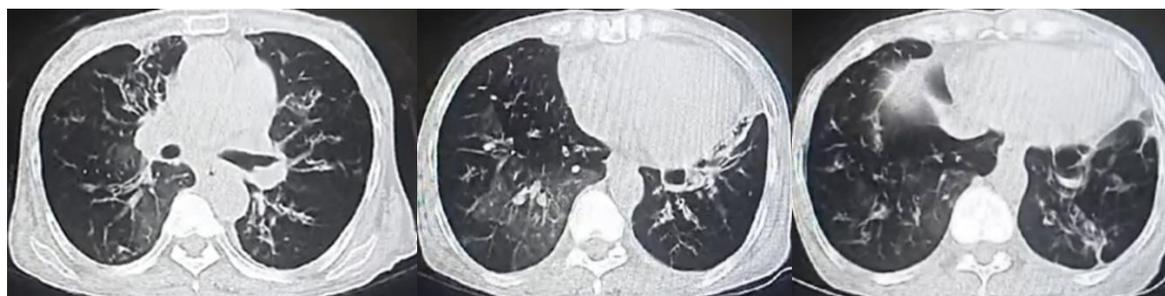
High-resolution computed tomography of the lungs showing bilateral bronchiectasis in lower lobes of lung.
